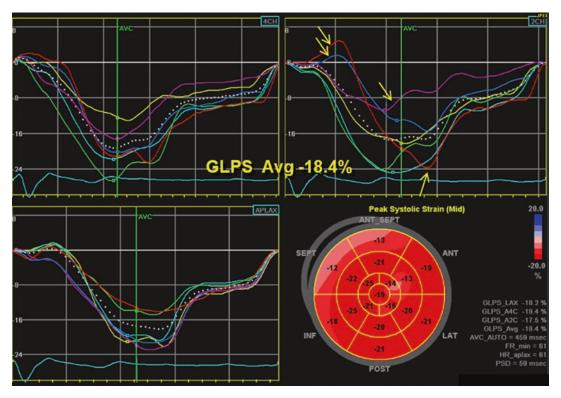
The three view strain set is from a patient with mitral insufficiency. The strain curves in the left hand panels (apical four and three chamber views are normal) loosely resemble each other in amplitude and timing. The upper right panel is from the apical two chamber view and shows bulging red walls in the red, blue and purple curves
